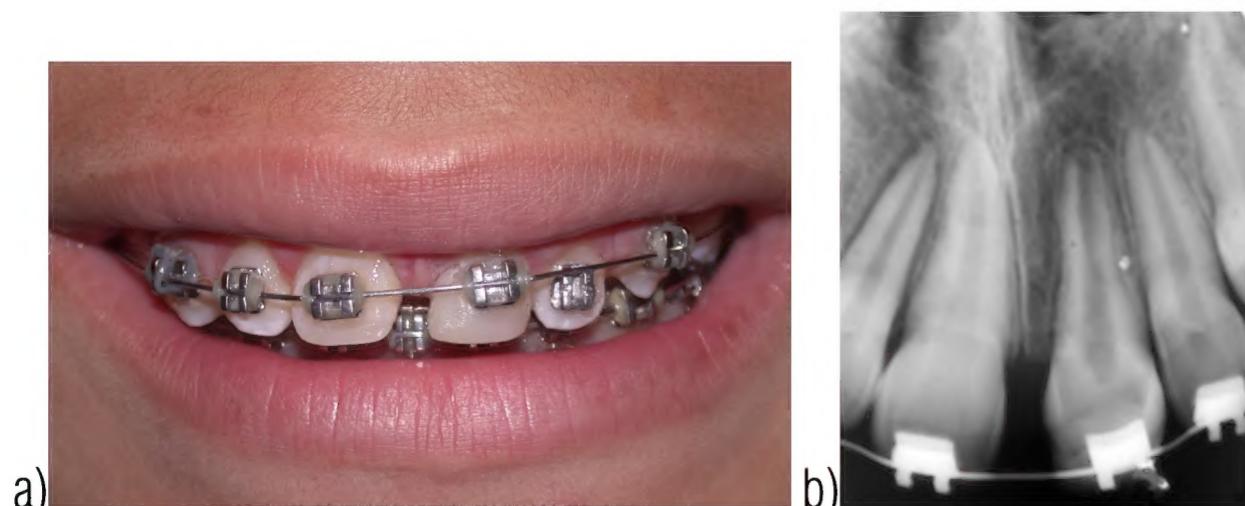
a) Two months follow-up; b) periapical radiograph.
